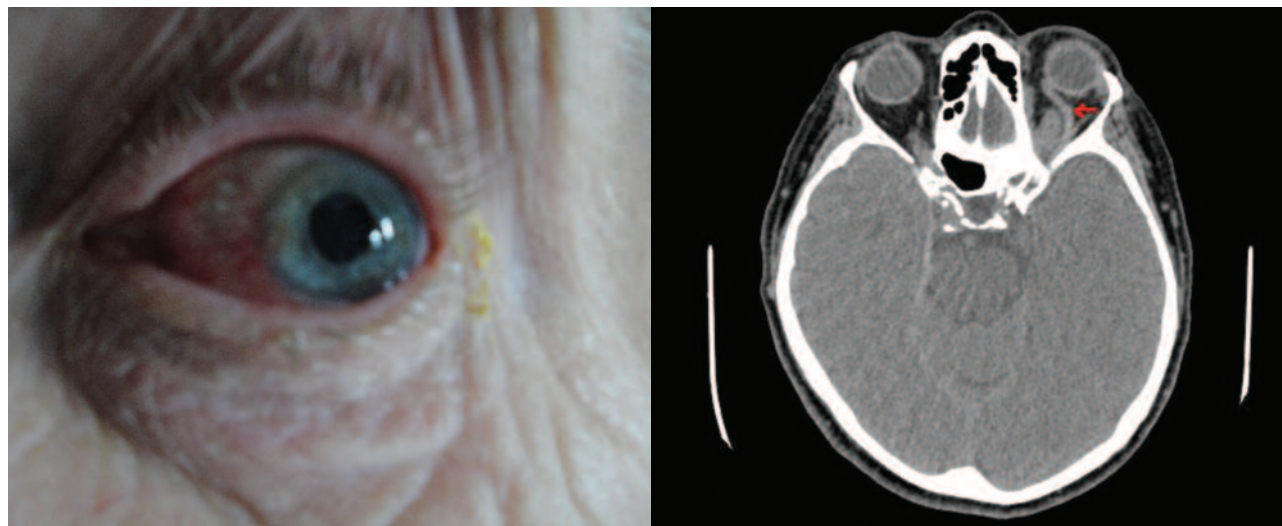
Left eye with conjunctival injection and deviation in abduction (left). Dilatation of the left superior ophthalmic vein on CT scan without contrast (right).
